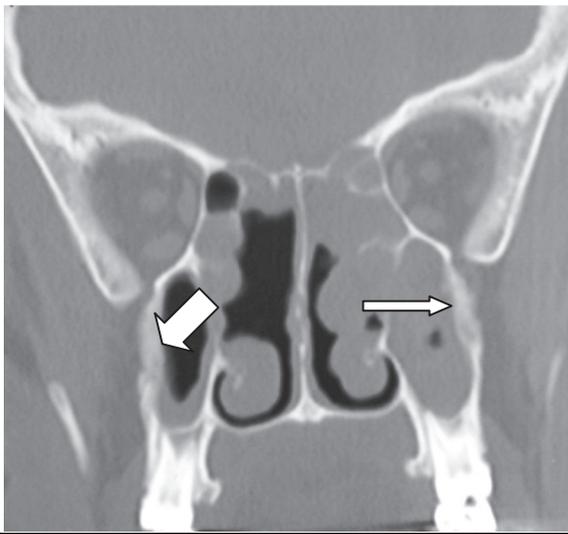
Coronal CT scan showing thickening and rarefaction of lateral maxillary walls (arrows).
